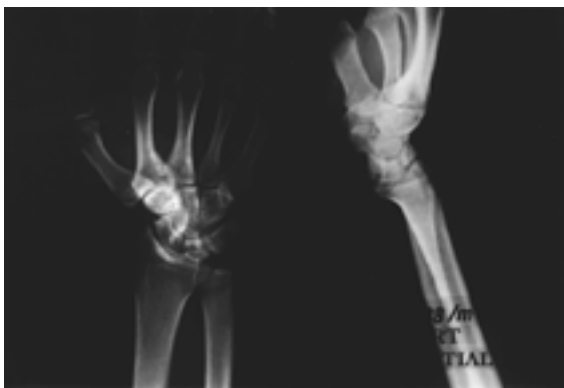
Anteroposterior and lateral view of wrist of 38-year-old men with Lichtman stage III of Kienbock disease. Radiograph showed sclerosis on lunate.
